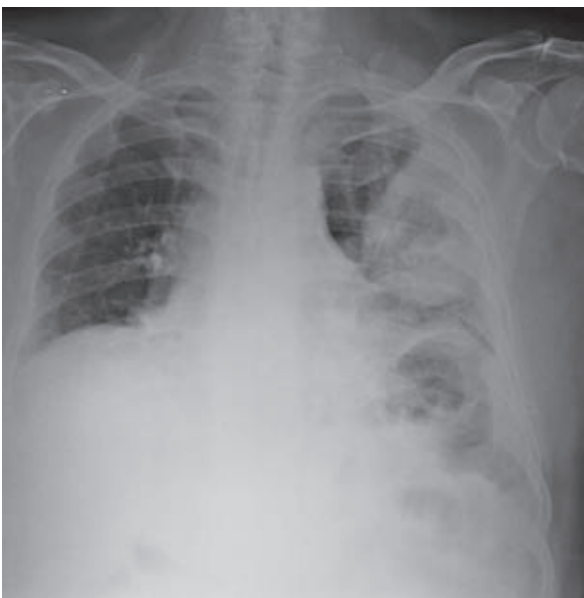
Chest X-ray. It shows a ball-shaped cavitated mass with crescentic cavitation in the posterior segment of the left upper lobe.
